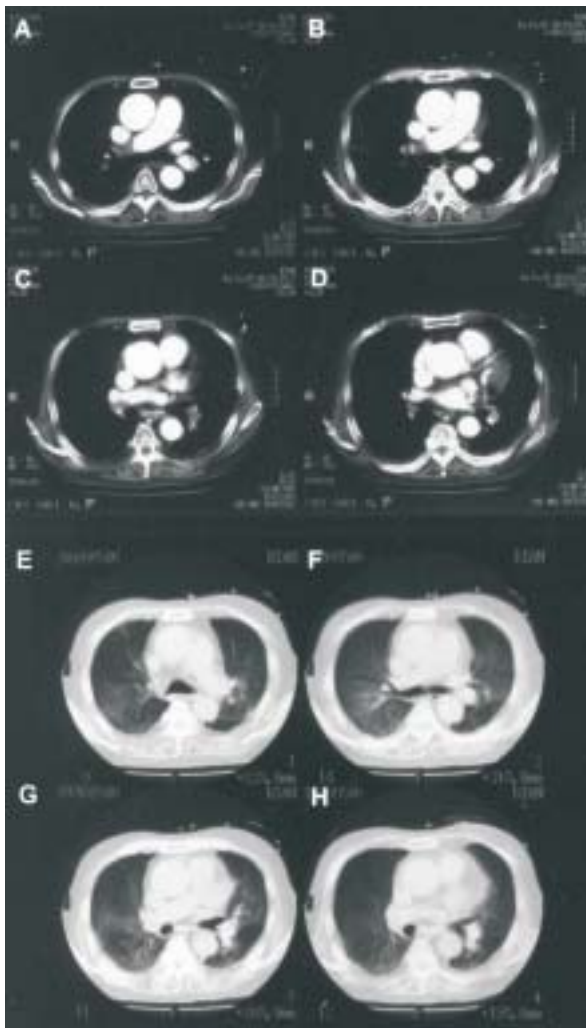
Computed tomography of the chest with and without intravenous contrast enhancement: (A-D) show evidence of filling defects on pulmonary arteries (centrally) of both sides and their descending branches, indicative of pulmonary embolism; (E-H) lung window images, show avascular zones in right middle lobe and left lower lobe.
